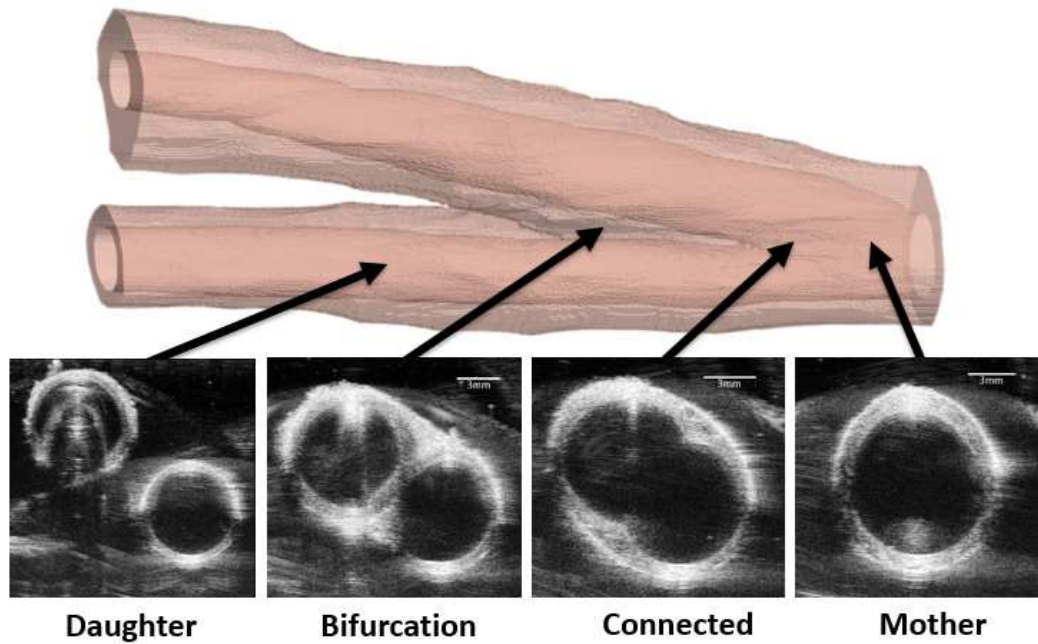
Reconstructed bifurcation with representative ultrasound images.
